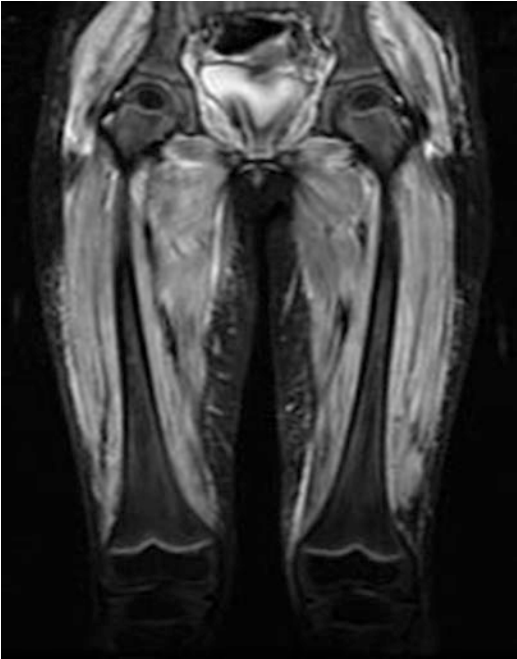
Magnetic resonance image of the hip girdle muscles in a child with juvenile dermatomyositis. (Image courtesy: Kathryn (Cassie) Torok)
